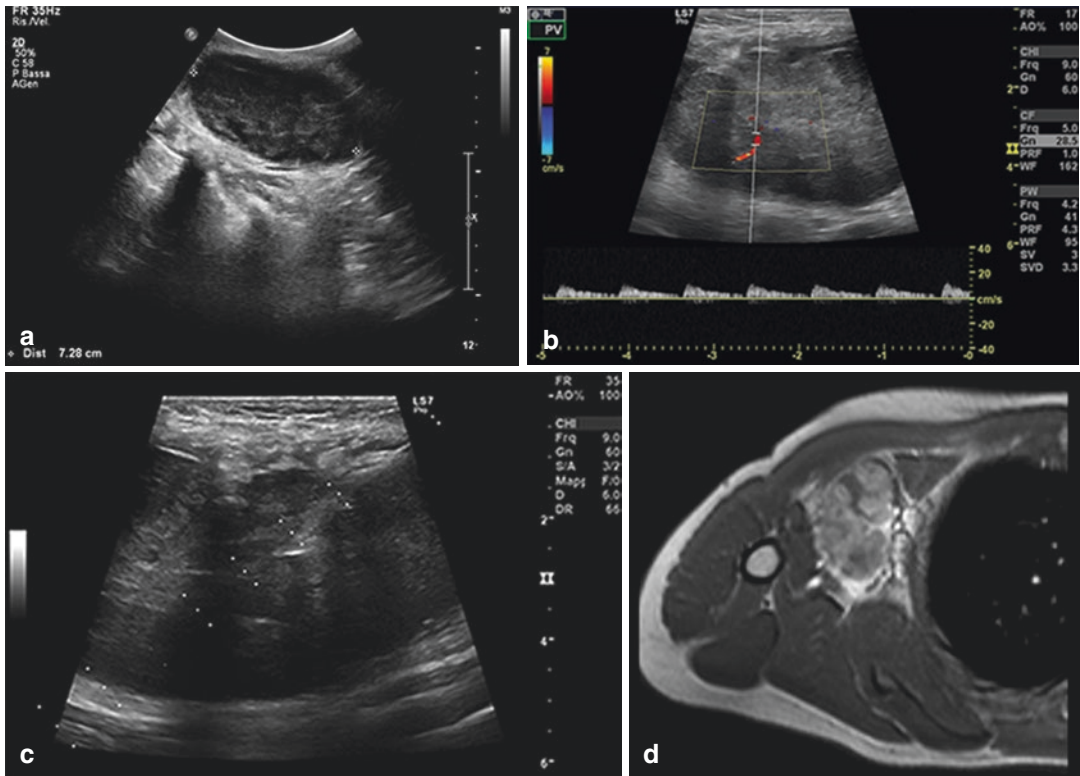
Metastases of the chest wall. TUS with convex probe (a), linear probe with Doppler colour (b), echo-guided biopsy (c), and MRI (d): T1W axial image after administration of contrast medium. Solid oval formation of soft tissues (max. diameter 8 cm) with an
